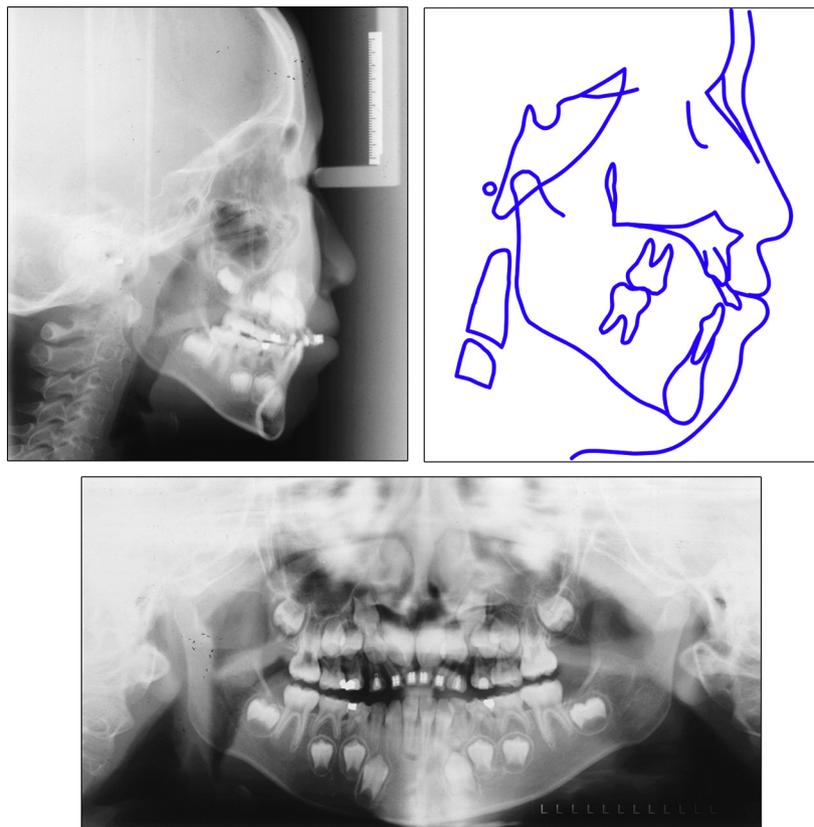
Lateral cephalogram and tracing and panoramic radiograph after protraction.
